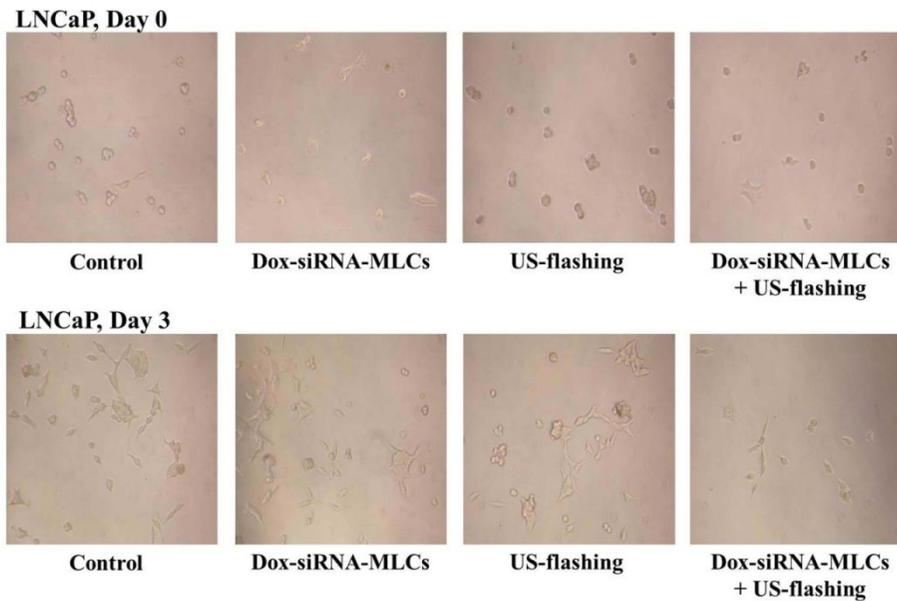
Clonogenic MTT assay of LNCaP cells on day 0 and day 3. Cell viability of the group treated with Dox-siRNA-MLCs and following ultrasound exposure shows significant reduction on day 3.
